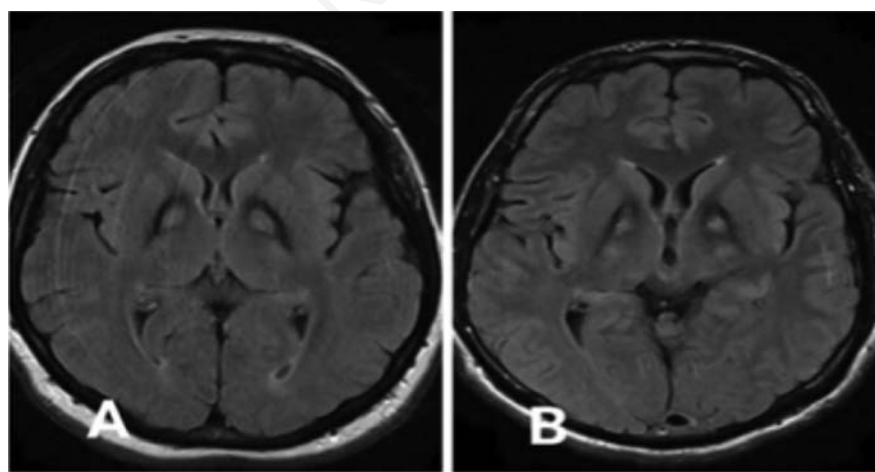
Brain magnetic resonance imaging T2-FLAIR images of case 1 (A) and 2 (B) revealed the eye of the tiger sign.
